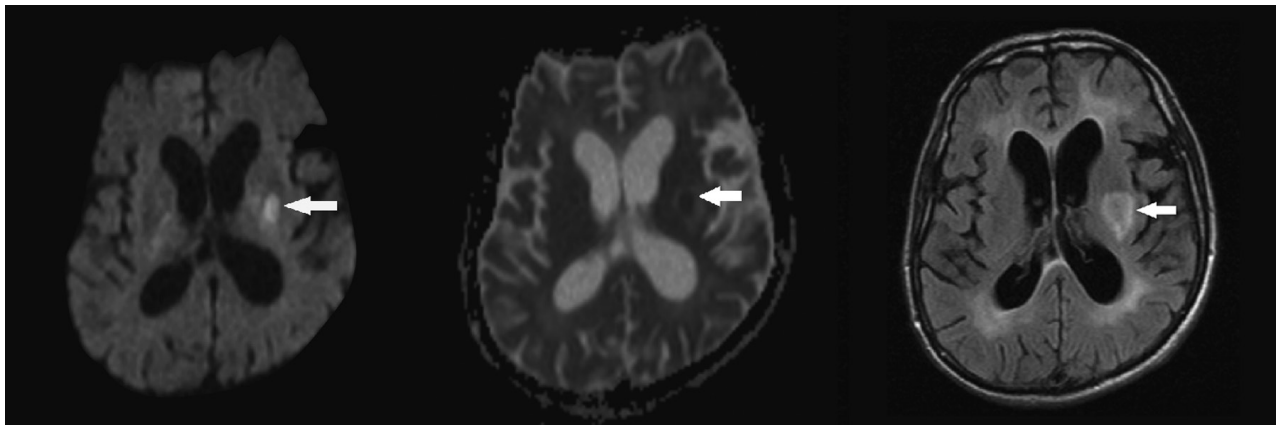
Magnetic resonance imaging performed on admission. Hyperintense lesion in the left lentiform nucleus on axial diffusion-weighted and fluid-attenuated inversion recovery sequences. Subcortical atrophy and ventricular dilatation
